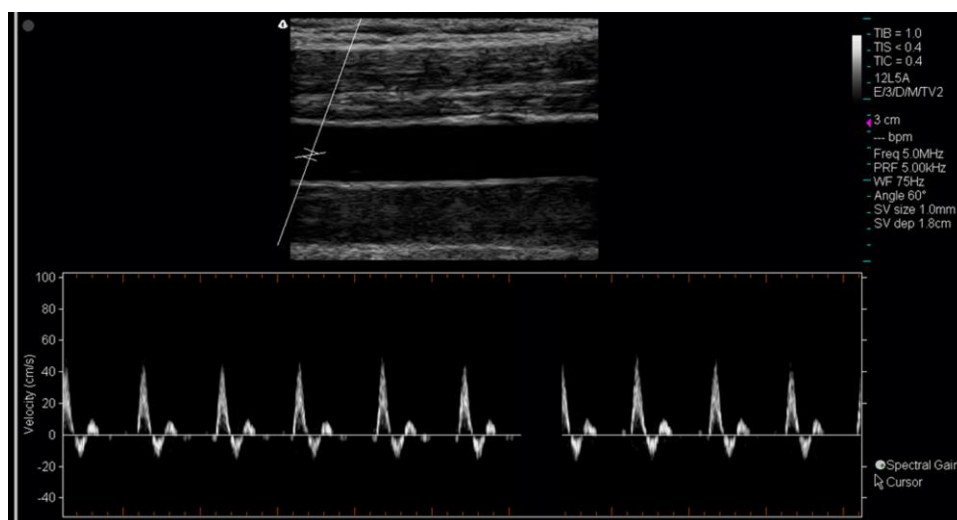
Ultrasound image of superficial femoral artery during pulse wave mode
